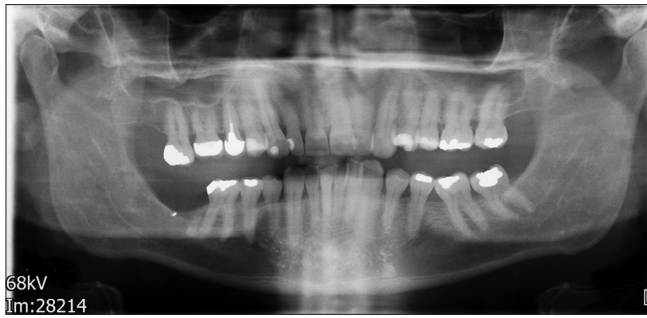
Panoramic radiograph. No obvious odontogenic or bony pathology is noted
